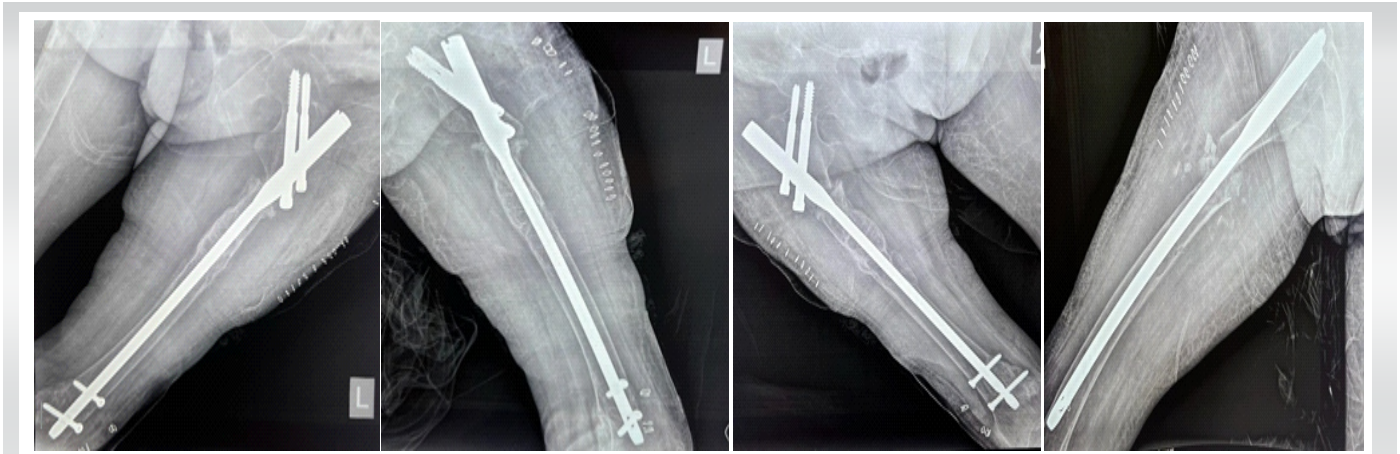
Immediate Post operative radiographs of bilateral femur operated with cephalomedullary nail fixation.
